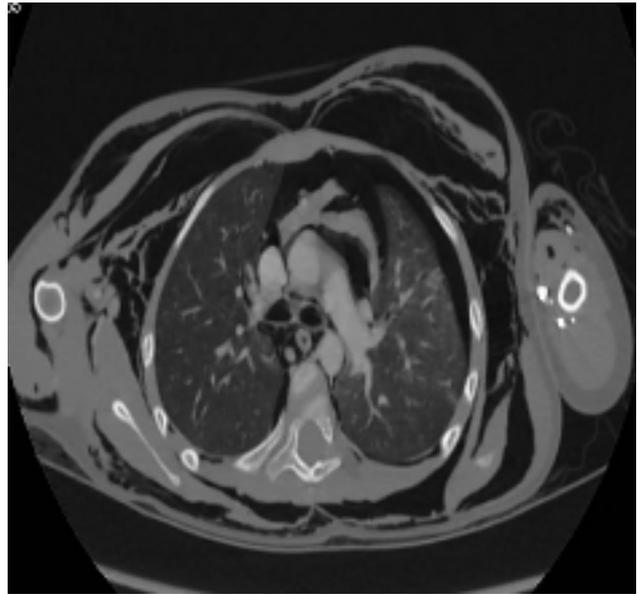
Left side pneumothorax, pneumomediastinum and subcutaneous emphysema in Thorax CT images
